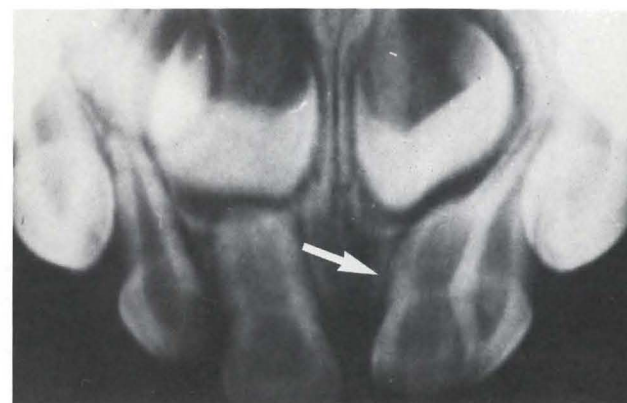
Periapical radiograph of fused maxillary left primary central and lateral incisors.
